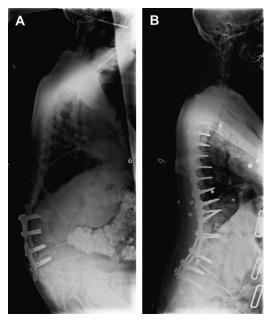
(A) Radiograph of a patient with iatrogenic fixed lumbar kyphosis. Note the posterior rotation of the pelvis and retroversion of the sacrum in an attempt to compensate for the profound sagittal imbalance. (B) After surgery, sagittal balance and normalized sacral-pelvic orientation are restored with two pedicle subtraction osteotomies, achieving almost 70° of correction in the sagittal plane.
